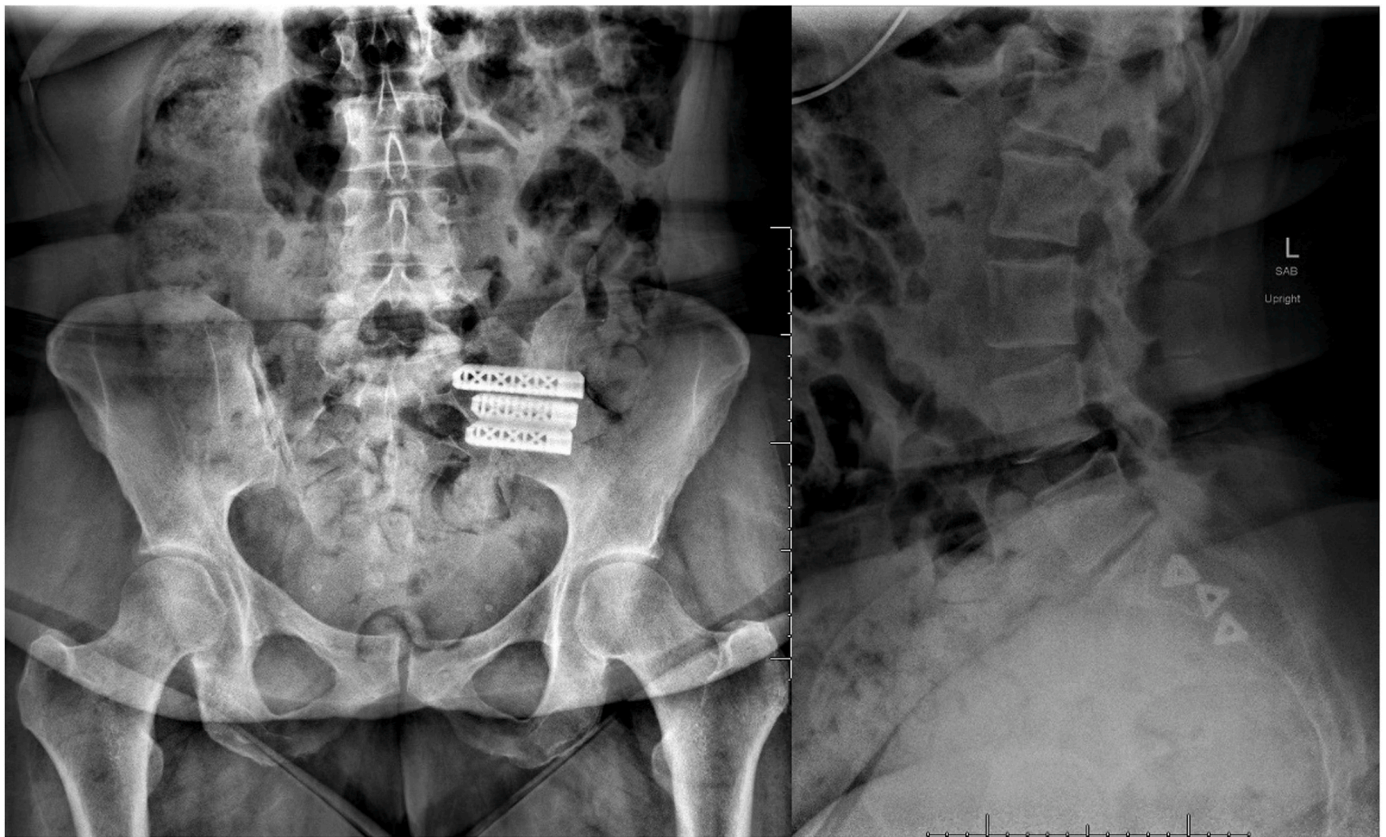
Postoperative X-ray for lateral approach SIJF.
